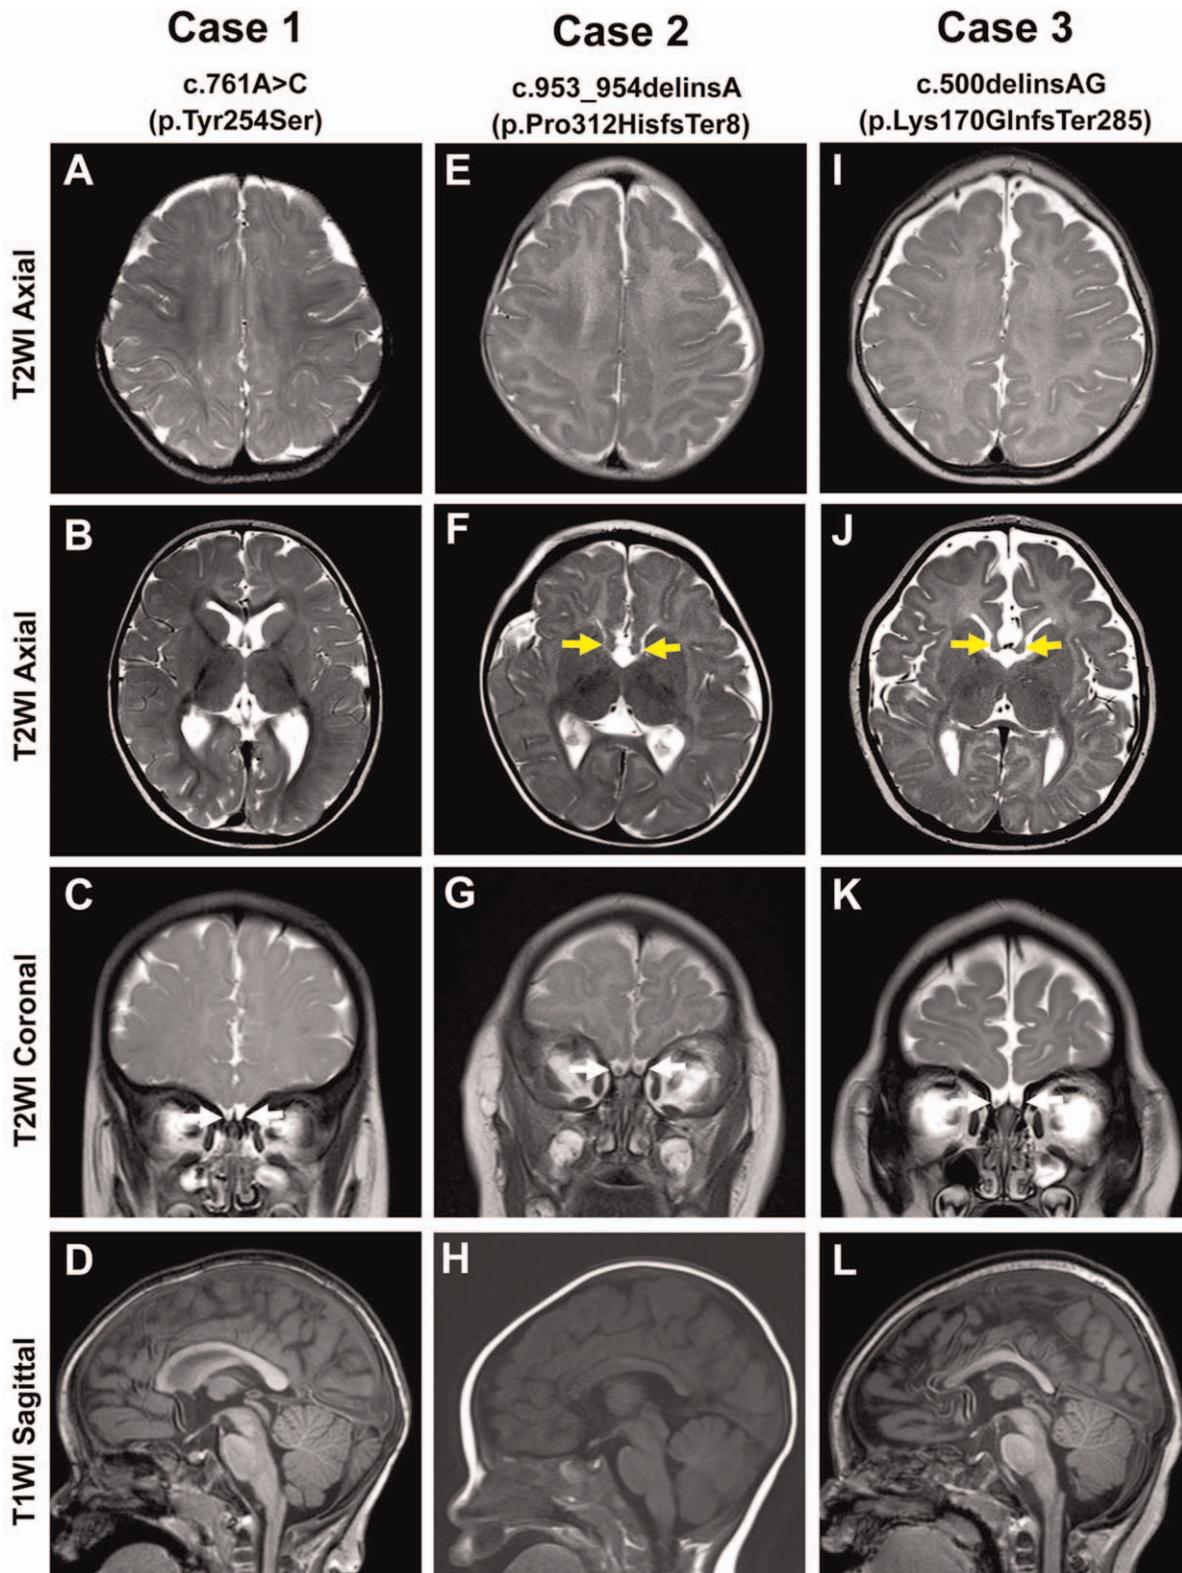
MRI findings of patients with *FOXP1*-related syndromes. Case 1 MRI obtained at 13 months of age. The lateral ventricles are mildly enlarged on the T2W axial images of the brain (A, B), and the bilateral olfactory bulbs appear small (white arrows) on the T2W coronal image (C). Sagittal T1-weighted MRI of the brain shows mild thinning of the corpus callosum (D). Case 2 MRI obtained at 6 months of age. The fronto-temporal lobes and the bilateral basal ganglia appear slightly small (E), the fornices appear enlarged and separated (yellow arrows, F), and the olfactory bulbs appear slightly small (white arrows, G). Sagittal T1W image displays the dysgenetic corpus callosum with absent rostrum and thinning of the posterior body and splenium (H). Case 3 MRI obtained at 7 months of age. The fronto-temporal lobes and the bilateral basal ganglia appear slightly small with suspicious slightly simplified gyral pattern (I, J), and the fornices appear enlarged and separated (yellow arrows, J). The ventricles are not dilated, but there is prominence in the extra-axial CSF (J), and the olfactory bulbs appear hypoplastic (white arrows, K). Sagittal T1W image displays the dysgenetic corpus callosum with absent rostrum and overall thinning especially of the posterior body and splenium (L).
